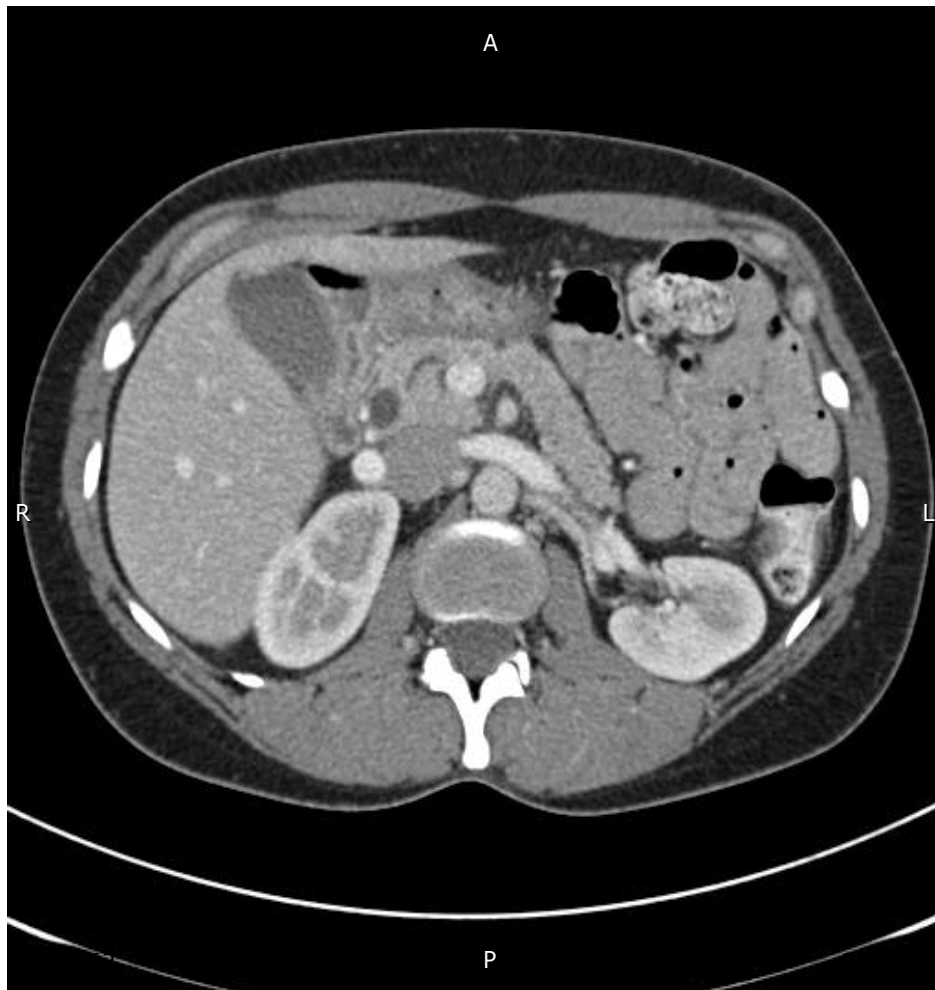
Post EUS-FNA CT showing – cyst without wall disruption and normal pancreas.
